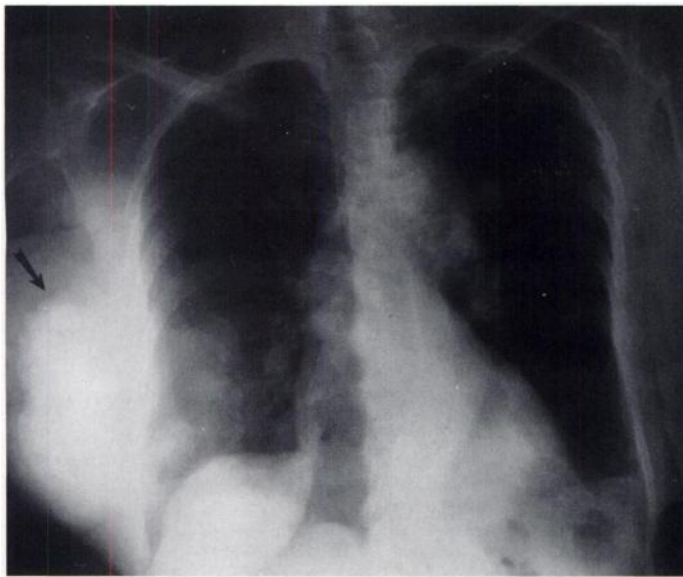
Chest radiograph demonstrates large right breast mass with evidence of calcification (arrow). Bilateral pulmonary nodules reflect metastatic disease.
